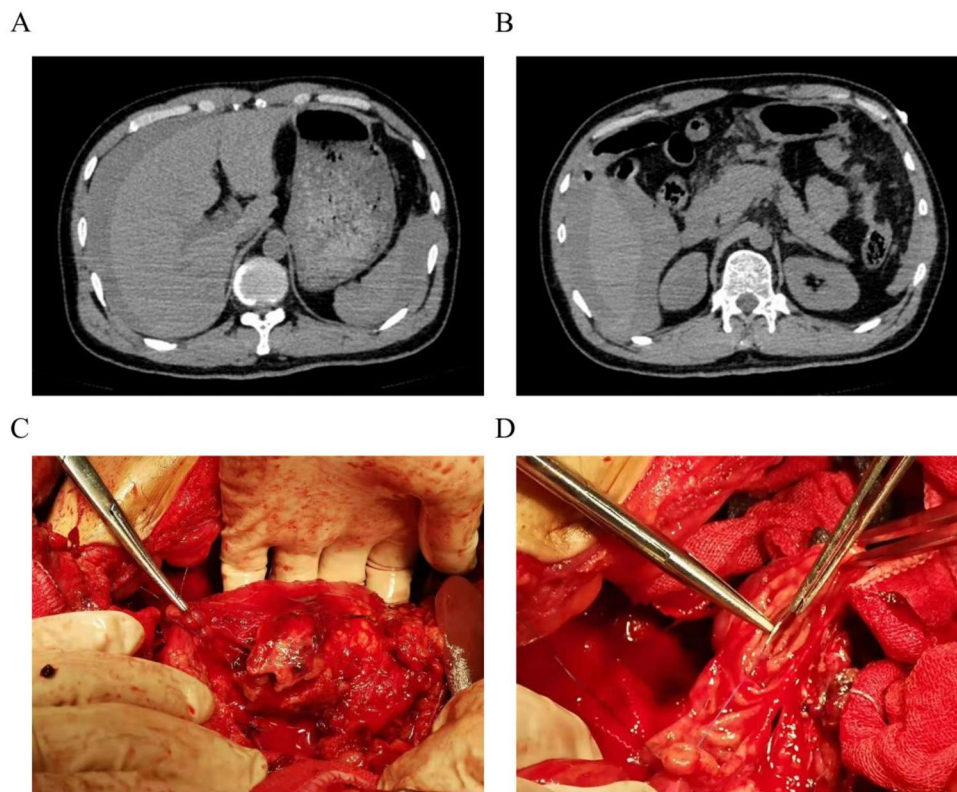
Preoperative CT images and intraoperative exploration of one patient. (A) CT image: abdominal fluid. (B) CT image: swollen pancreatic head. (C) Massive disruption of the pancreatic head. (D) Disruption of the horizontal part of the duodenum
